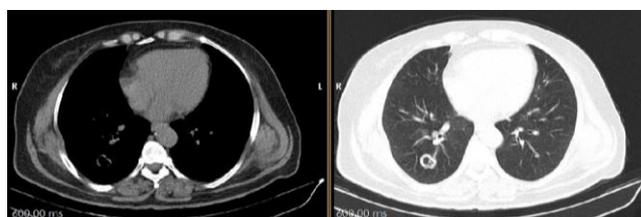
Thoracic CT scan revealed cavity in right hemithorax
